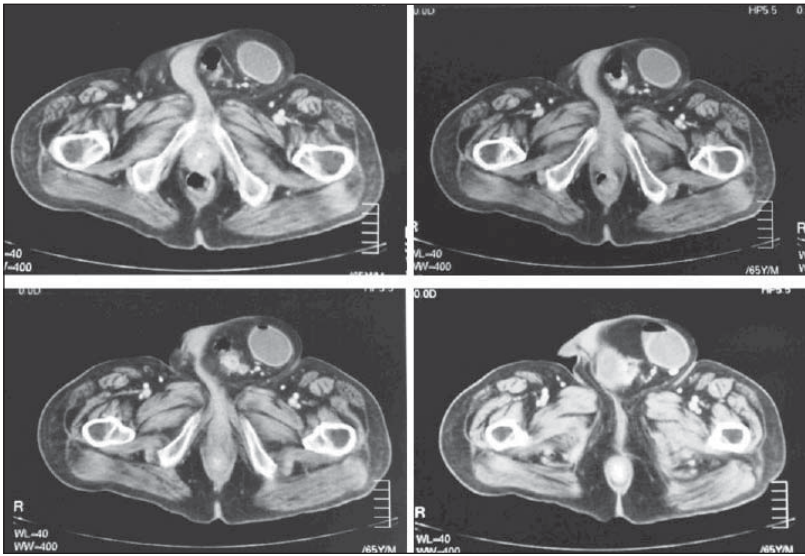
CT that shows sigmoid cancer in a non-reducible inguinal hernia
